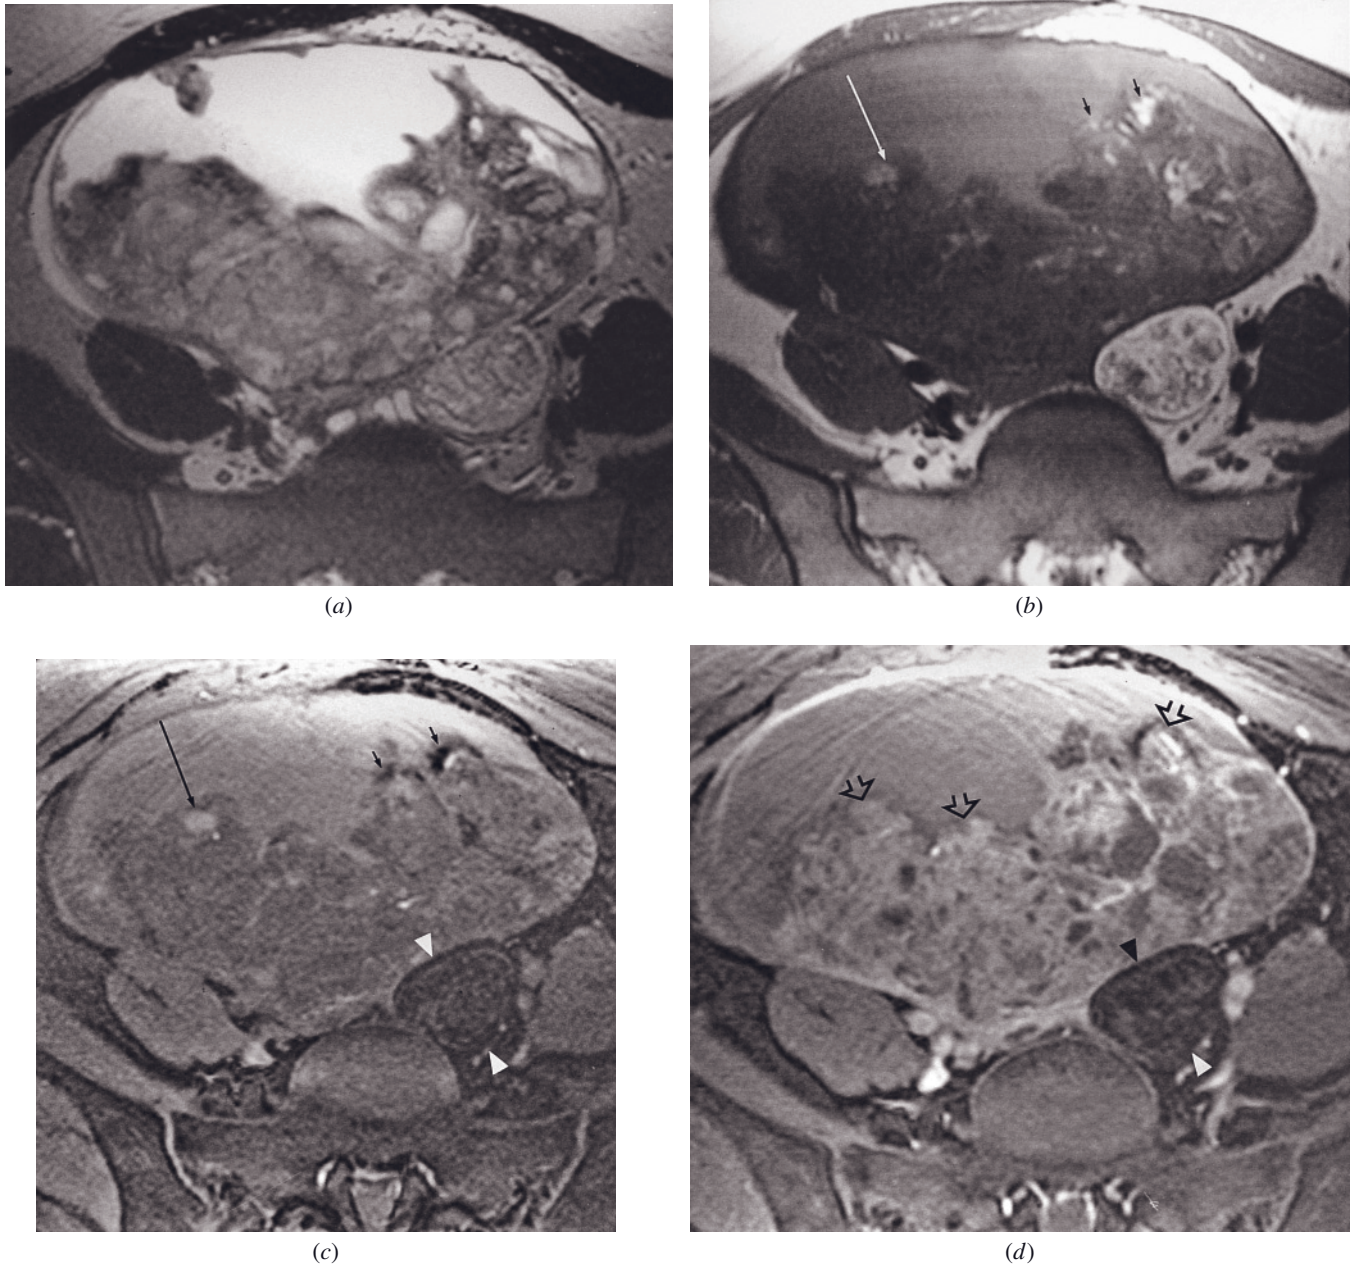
Mature and immature teratomas. T2-weighted ETSE (a), T1-weighted SE (b), T1-weighted fat-suppressed gradient-echo (c), and gadolinium-enhanced T1-weighted fat-suppressed gradient-echo (d) images in a patient with complex right adnexal masses. The two masses have variable amounts of fatty elements, which are high in signal intensity on the conventional T1-weighted SE image and suppress on the fat-suppressed images (short arrows, b, c). Note that some of the high-signal-intensity foci in the larger mass retain their high signal intensity on the fat-suppressed images, which is consistent with coexisting hemorrhage (long arrow, b, c). The smaller posterior mass shows nearly complete suppression on the fat-suppressed image (arrowheads, c). After contrast, there is a profusion of solid tissue enhancing in the larger mass (open arrows, d). The smaller mass does not enhance appreciably, which is consistent with a cystic structure (arrowheads, d). Extensive solid elements in a fat-containing mass are atypical of a dermoid cyst and should raise the suspicion of an immature teratoma. This was proven at surgery, whereas the posterolateral mass turned out to be a mature teratoma (dermoid cyst). (reprinted with permission from Outwater EK, Dunton CJ: Imaging of the ovary and adnexa: clinical issues and applications of MR imaging. *Radiology* 194: 1-18, 1992.)
